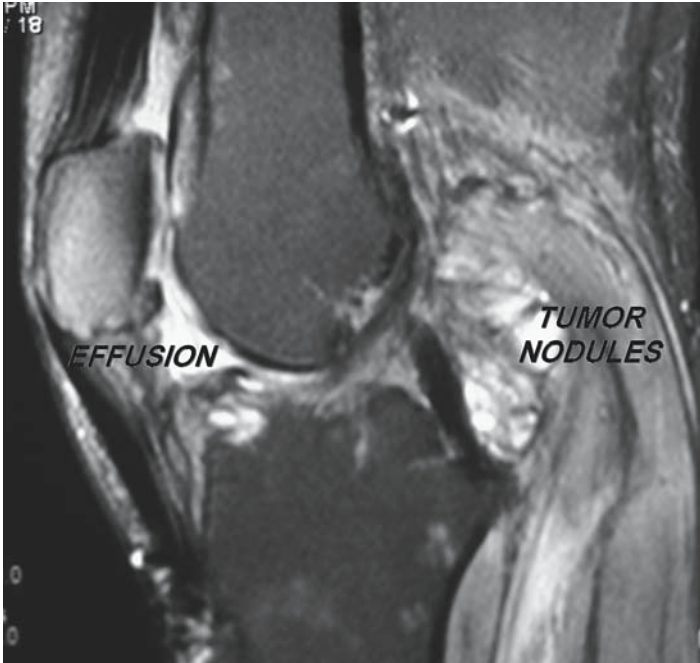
Pigmented villonodular synovitis. Magnetic resonance imaging (MRI) demonstrates pigmented villonodular synovitis (PVNS) of the knee. PVNS is the most common neoplastic lesion of the synovium. Note the fullness and effusion within the joint.
